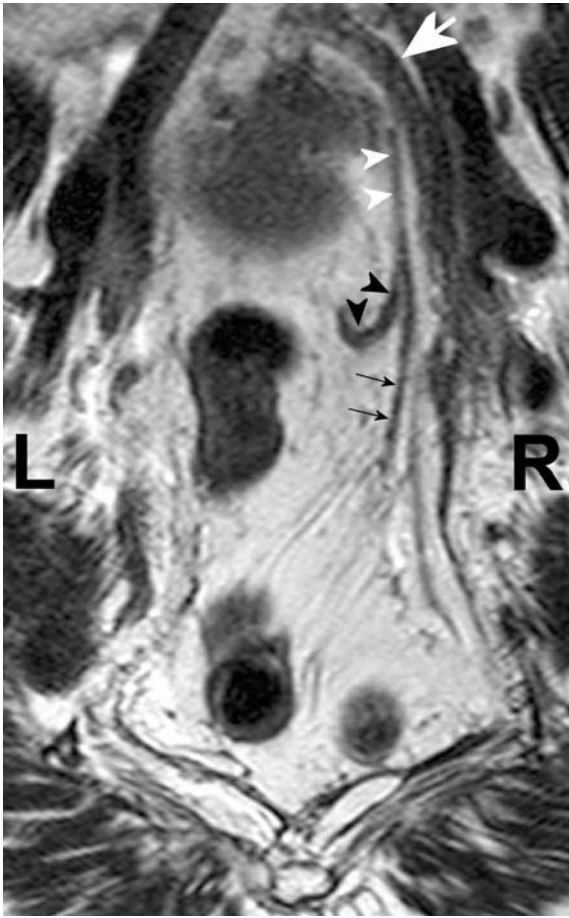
55. On sagittal T2-weighted fast spin echo (TR/TE 4,598/150 ms) magnetic resonance image the superior rectal artery and its branches can be detected as low signal intensity, tubular structures in the presacral region (*white arrowheads*). The superior rectal vein runs on the dorsal and left side of the artery (*black arrowheads*)
